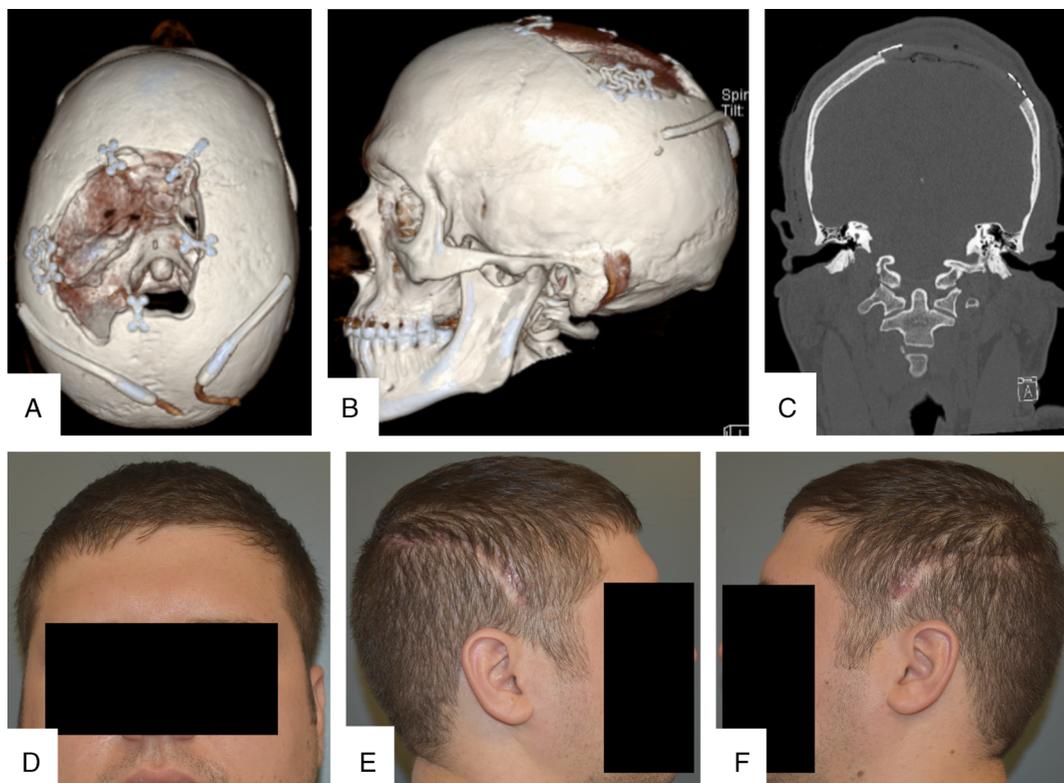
Postoperative images of the single-stage cranioplasty case demonstrated in Figure 1. A and B, Horizontal and lateral views of 3D reconstructed CT scan showing cranial implant. Temporary postoperative drains are also seen. C, Coronal view of CT scan showing the implant in the bone defect. Note that the titanium plates securing the implant are visible; however, the implant itself is radiolucent. D–F, Postoperative photographs of patient at 2 months. Note symmetric cranial contour and appropriately healing incisions.
